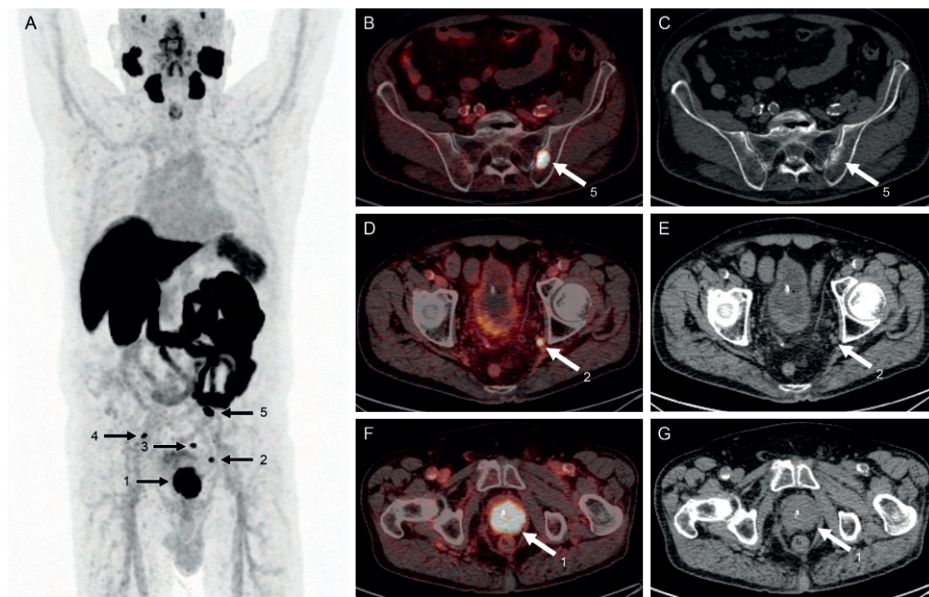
Staging [^{18}F]PSMA-1007 PET/CT of a patient with prostate cancer in the prostate (1), lymph node (2) and bone (3-5). Physiological uptake is observed in the small intestines, kidneys, liver, spleen, salivary glands and lacrimal glands. A: Maximum intensity projection. B, D, F: fused PET and CT images. C, E, G: CT images.
